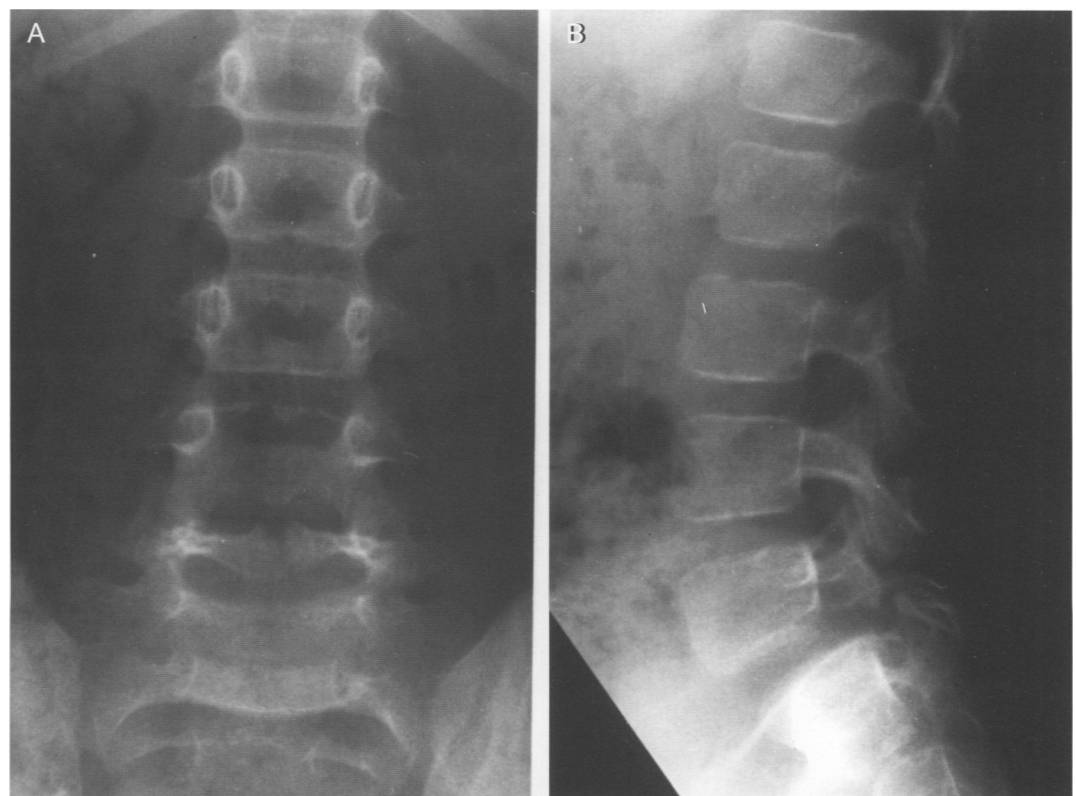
(A) Anteroposterior and (B) lateral radiographs of the lumbar spine showing a grade 1 spondylolisthesis at L5/S1 together with a defect of the pars interarticularis of L5. Note the loss of definition of the inferior and superior endplates of L2 and L3 respectively. Note also the beaking of the L2 vertebral body antero-inferiorly.
